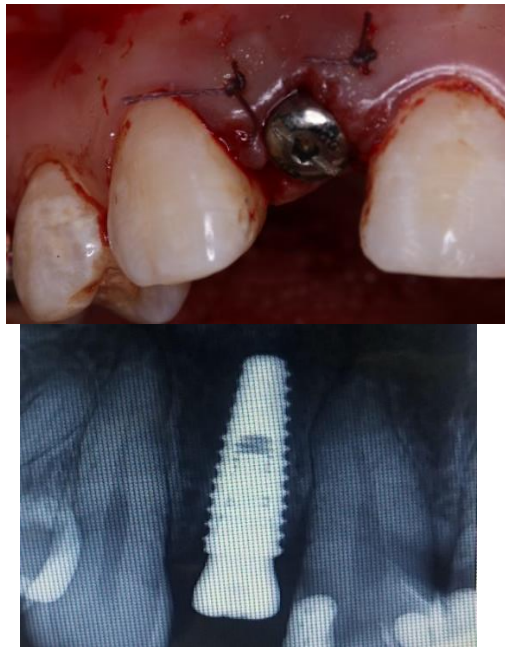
A gum shaper is installed on the implant. Stitches are supplied. Figure 14. X-ray image after implant placement
